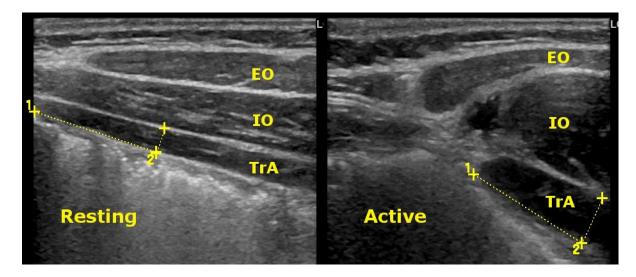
Example of ultrasound measurement of the transversus abdominis muscle. Left: Resting thickness. Right: Active thickness. EO = external oblique, IO = internal oblique, TrA = transversus abdominis. TrA thickness was measured as the distance between the hyperechoic muscle fascia lines two centimeters from the anterior muscle-fascia junction.
